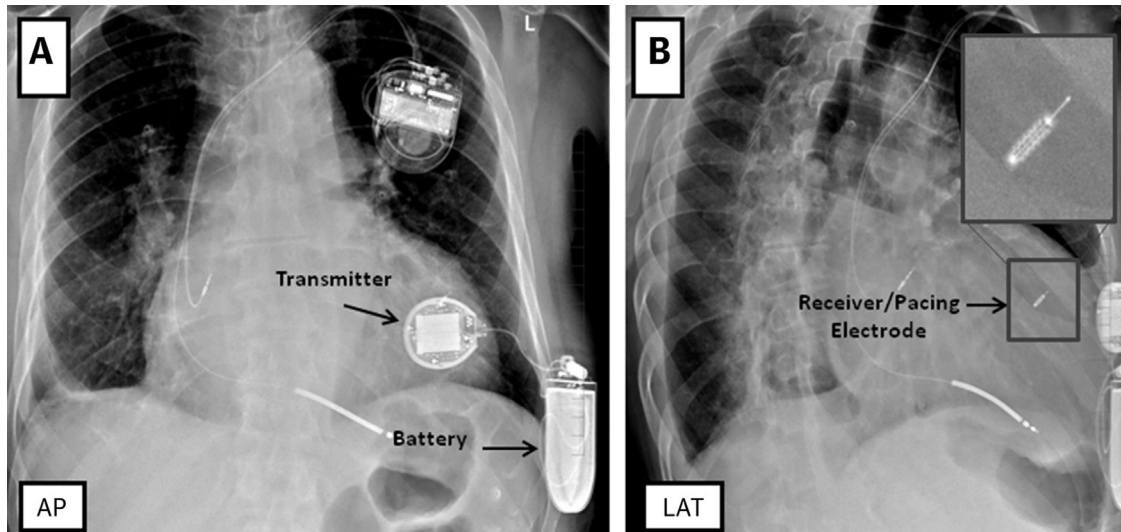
Anteroposterior and lateral chest radiographs demonstrating a wireless ultrasound endocardial pacing system. In addition, a dual-chamber device is present. With permission from Miller et al.<sup>45</sup>.
